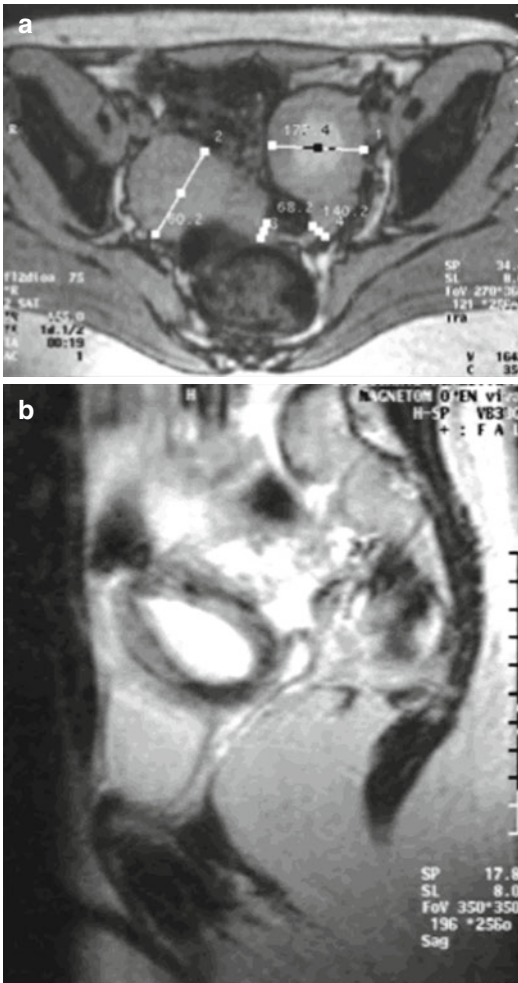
Complete bicorporeal uterus with LT unilateral cervical aplasia (ESHRE/ESGE Class U3bC3): (a) MRI image showing in the transverse plane the complete bicorporeal uterus with LT hematometra, (b) MRI image showing the LT cervical aplasia in the coronal plane
